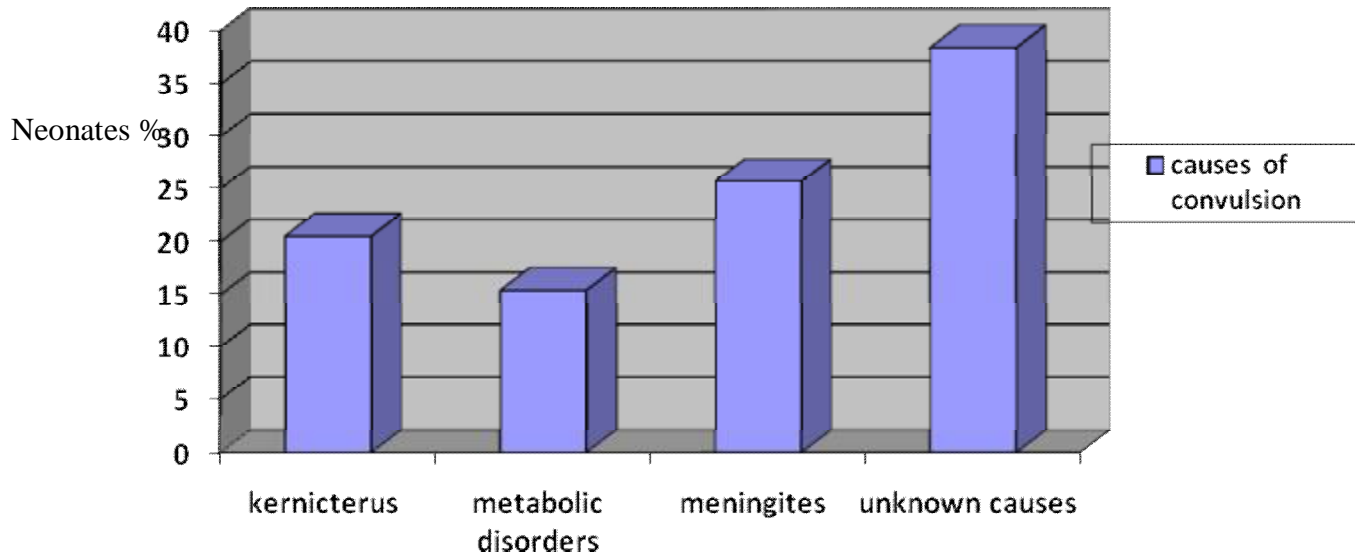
Causes of neonatal seizure in neonates with normal CT scan of the head .
